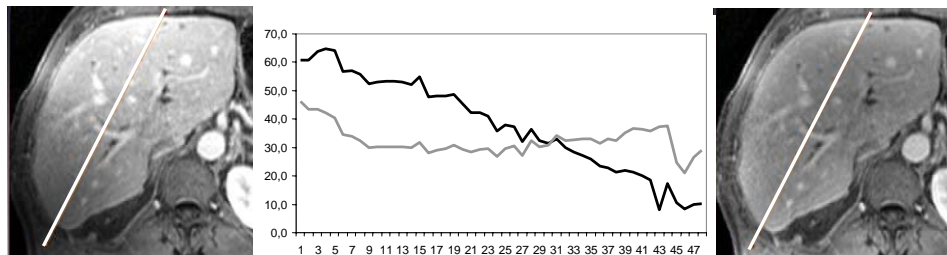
MR image slice without (left) and with inhomogeneity correction (right). The graph in the middle shows a grey value profile of the original (black) and corrected (grey) image data. The position of the profile is visualized in the image slice.
